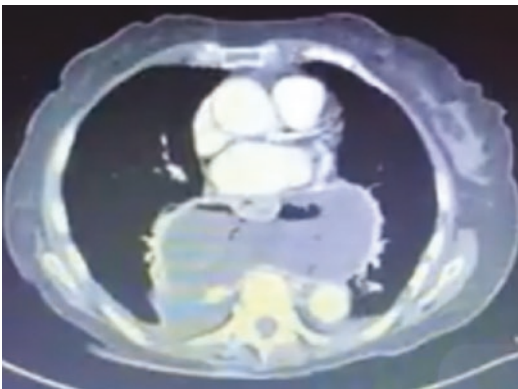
CT scan of the chest showing a mediastinal collection containing air and fluid with rim enhancement suggestive of an esophageal leak after a giant paraesophageal hernia repair
